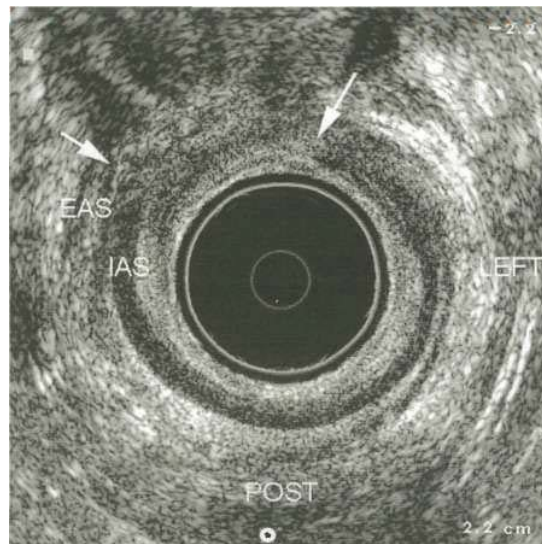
Endoanal ultrasound scan, axial mid canal image, showing a large tear between 10 and 1 o'clock (arrows) following vaginal delivery, involving the external (EAS) and internal anal sphincters (IAS) and resulting in faecal incontinence. Courtesy of Professor Clive Bartram, Princess Grace Hospital, London.
